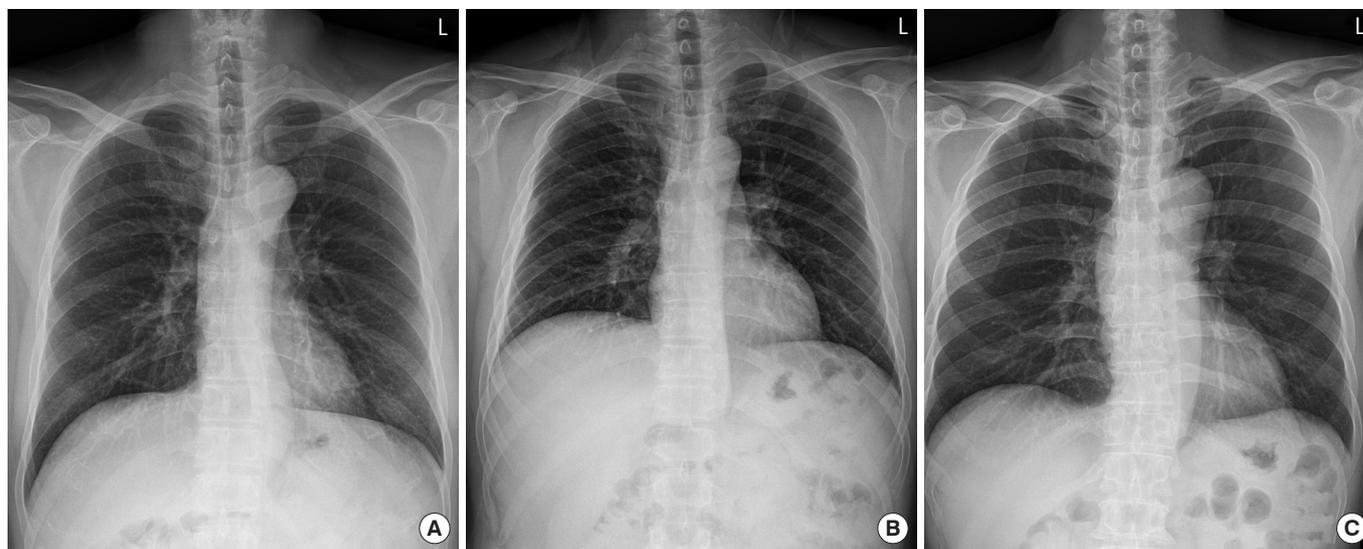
Chest radiographs of the patients. (A) Case 1, (B) case 2, and (C) case 3. L, left side.
